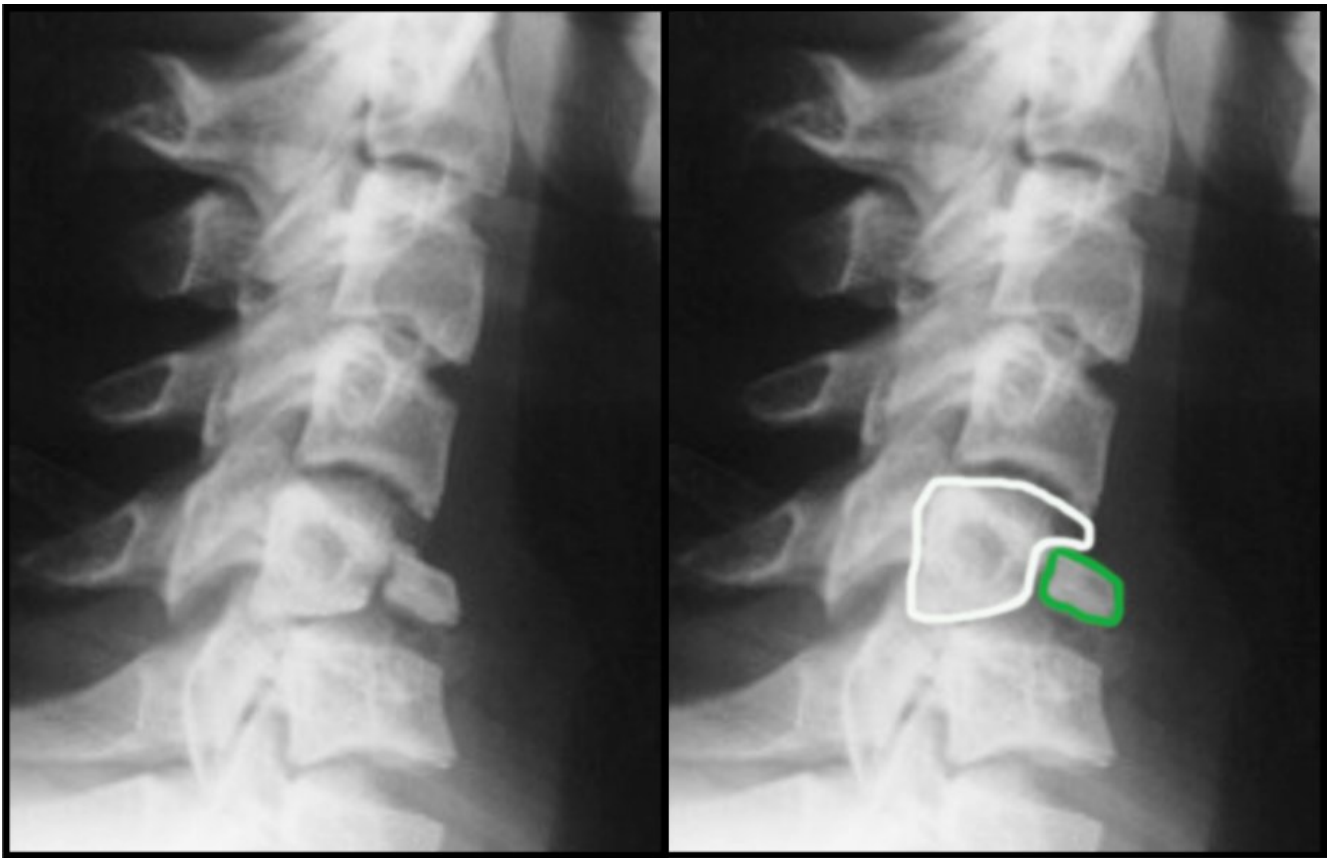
Flexion teardrop fracture.* Lateral cervical spine radiograph demonstrating a teardrop fracture, as outlined in green.
